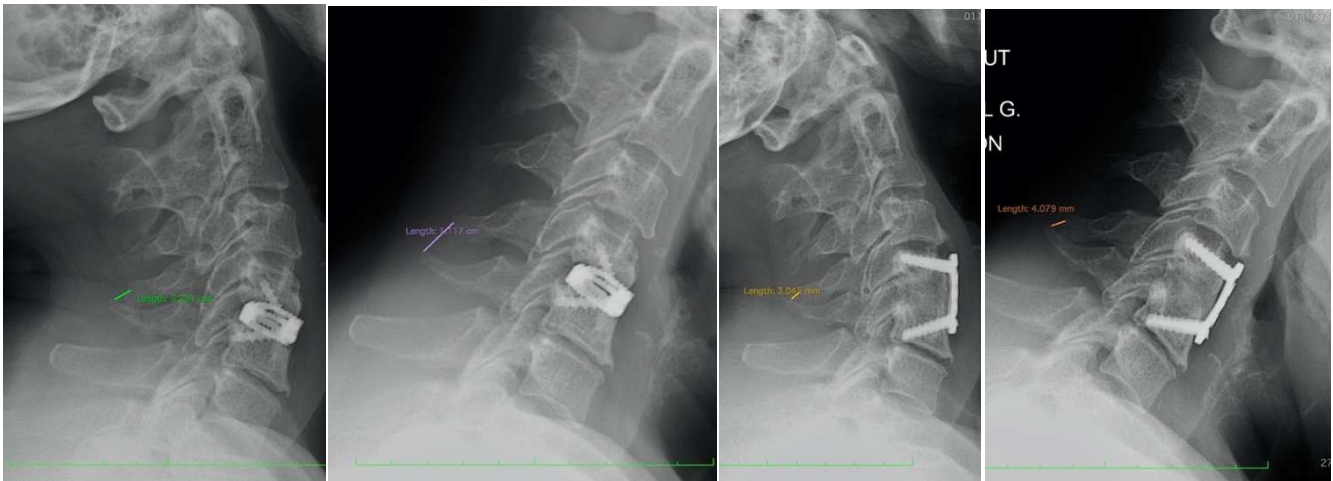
43 year-old female with C4-C5 fusion. At 11 months: dynamic X-ray showing 6mm mobility between views. Anterior revision by iliac graft: good radiological and clinical progression at 4 months (1 mm between hyperflexion and hyperextension: i.e., less than the 2 mm threshold)
